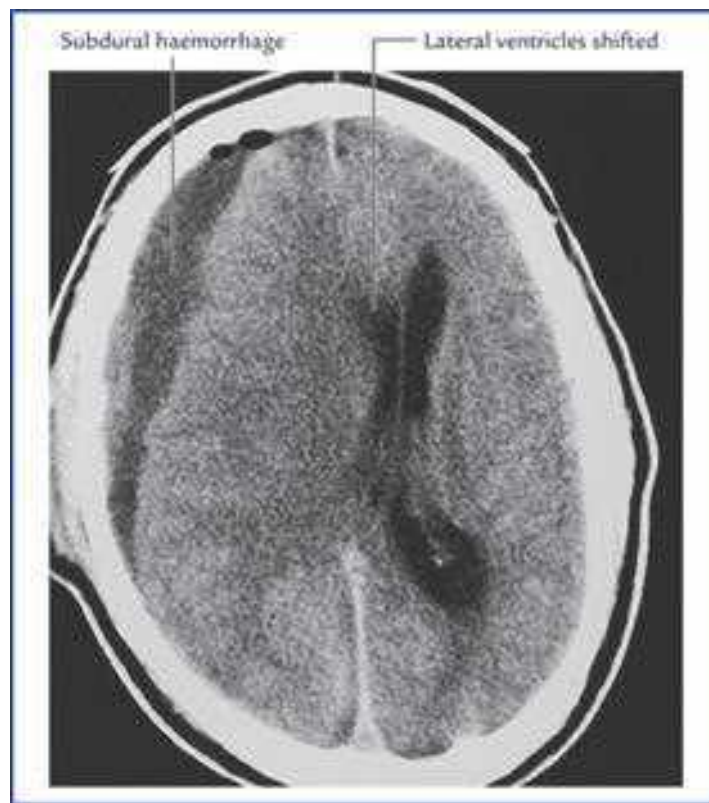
CT scan of brain showing subdural haemorrhage/ haematoma. Source: Drake, Richard L, Vogl, Mitchell, Adam WM. *Grays Anatomy for Students*. Philadelphia: Elsevier, Inc., 2005
